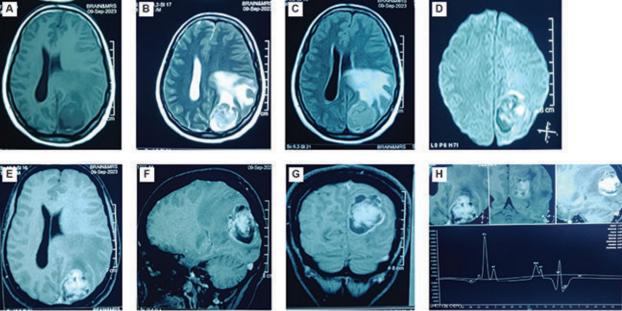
Preoperative (A) MRI axial T1 image showing hypo-intense irregular lesion occupying left occipital lobe adjacent to pole with perilesional hypo-intensity, effacement of left lateral ventricle, shifting of midline to right, (B) axial T2 iso to hypo-intensity with peri-lesional hyper-intensity, (C) which is also hyper-intense on FLAIR suggesting peri-lesional edema (D) patchy restriction of diffusion, (E) Heterogenous contrast enhancement with intralesional hypo-intensity(non-enhancing) may be necrosis on axial contrast, (F) sagittal contrast suggesting heterogenous contrast enhancing may be extra axial lesion surrounded by cystic fluid or CSF cleft (G) coronal contrast, (H) MRS showing high Choline peak, low NAA, Choline: Creatine- 3.85
